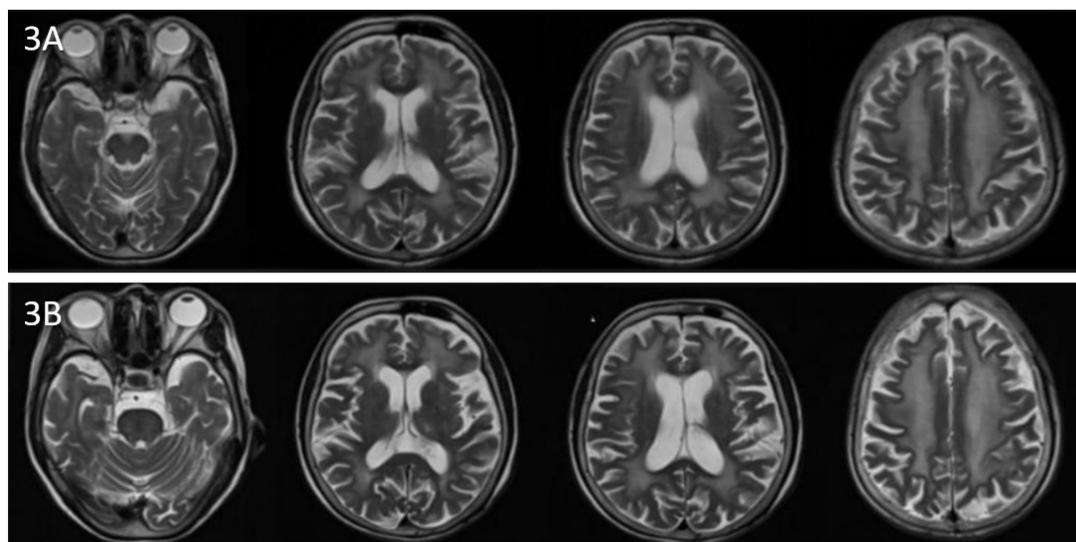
Progressive confluent white matter hyperintensities on T2-weighted imaging (T2WI). (A) Baseline scan (2023) demonstrating extensive symmetric periventricular hyperintensities (Fazekas grade 3). (B) Follow-up scan (2024) revealing increased confluence and patchiness of periventricular hyperintensity.
